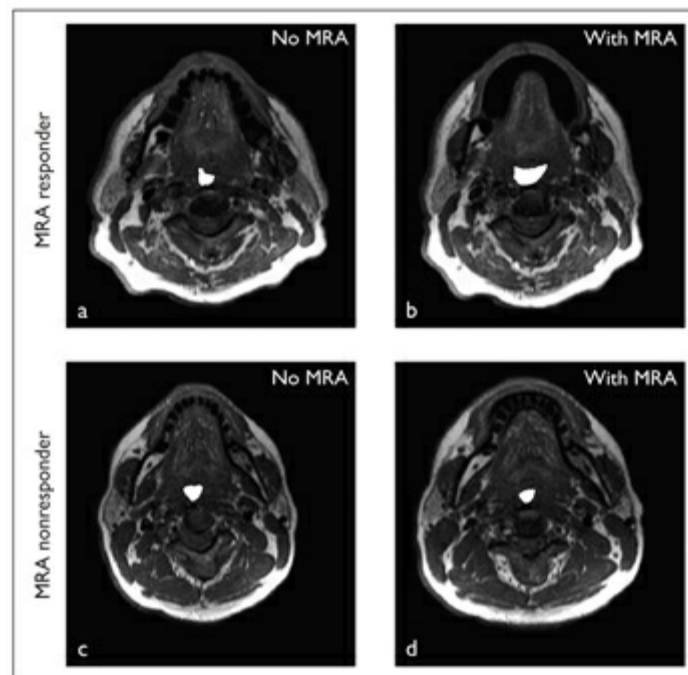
Axial magnetic resonance imaging sections at the retroglossal level in two patients with OSA, taken with and without an MRA. The MRA responder (*a and b*) shows an increase in lateral airway dimensions with the MRA, whereas the nonresponder (*c and d*) does not (airways are highlighted).
